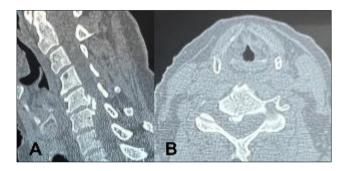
Cervical CT scan in sagittal bone view showing ossification of posterior longitudinal ligament in C5-C6 level (A) and in axial view (B)
